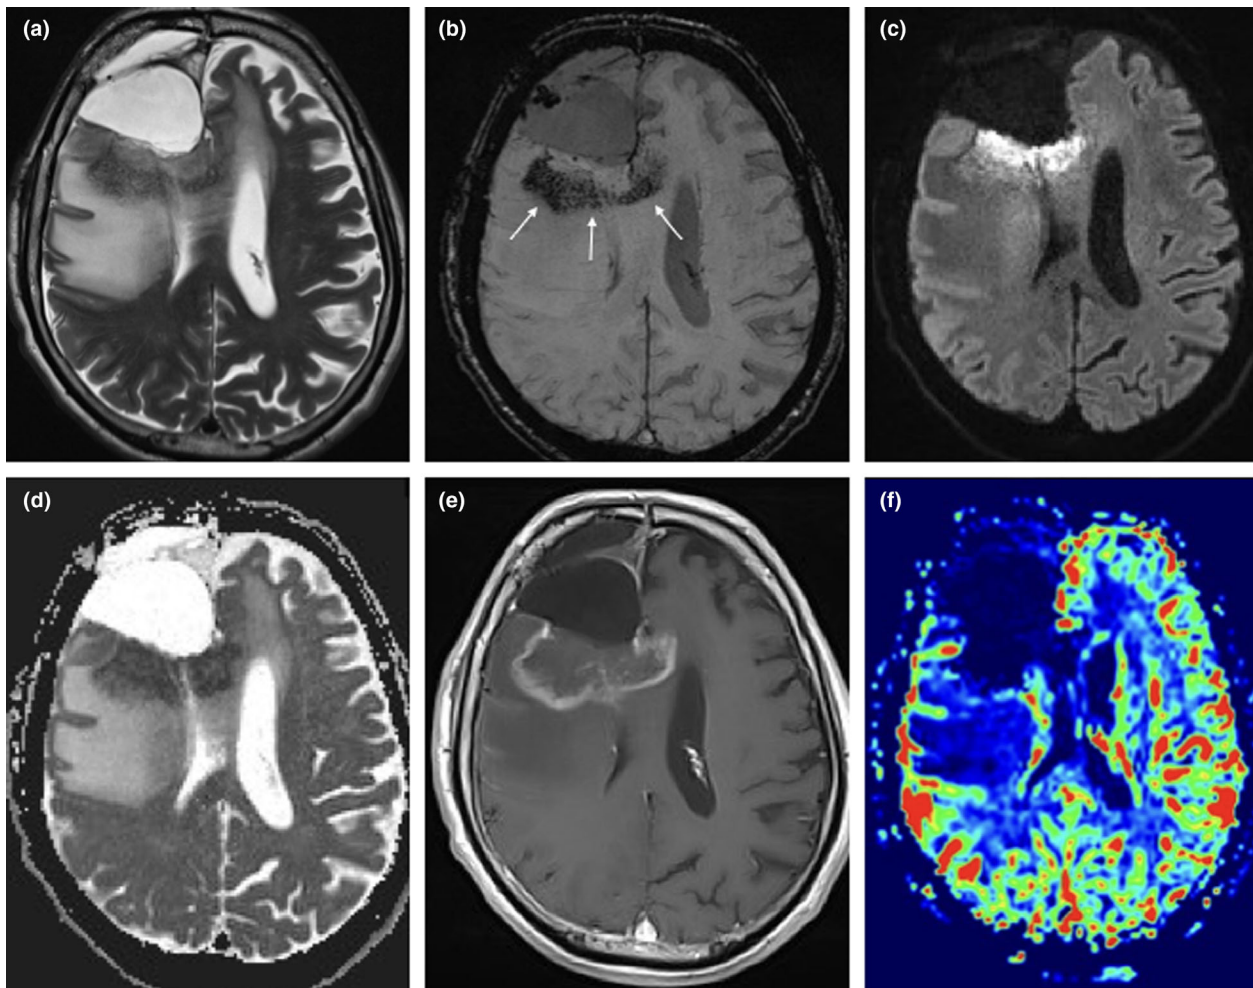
Diffuse T2 hypointensity along surgical borders surrounded by a diffuse oedema (a), with marked SWI hypointensity (b, white arrows), strong DWI restriction (c) with low ADC values (d) and T1 irregular contrast enhancement (e). PWI showed no higher rCBV with respect to surrounding parenchyma (f). DWI, diffusion-weighted imaging; PWI, perfusion-weighted imaging; rCBV, relative cerebral blood volume; SWI, susceptibility-weighted imaging.
